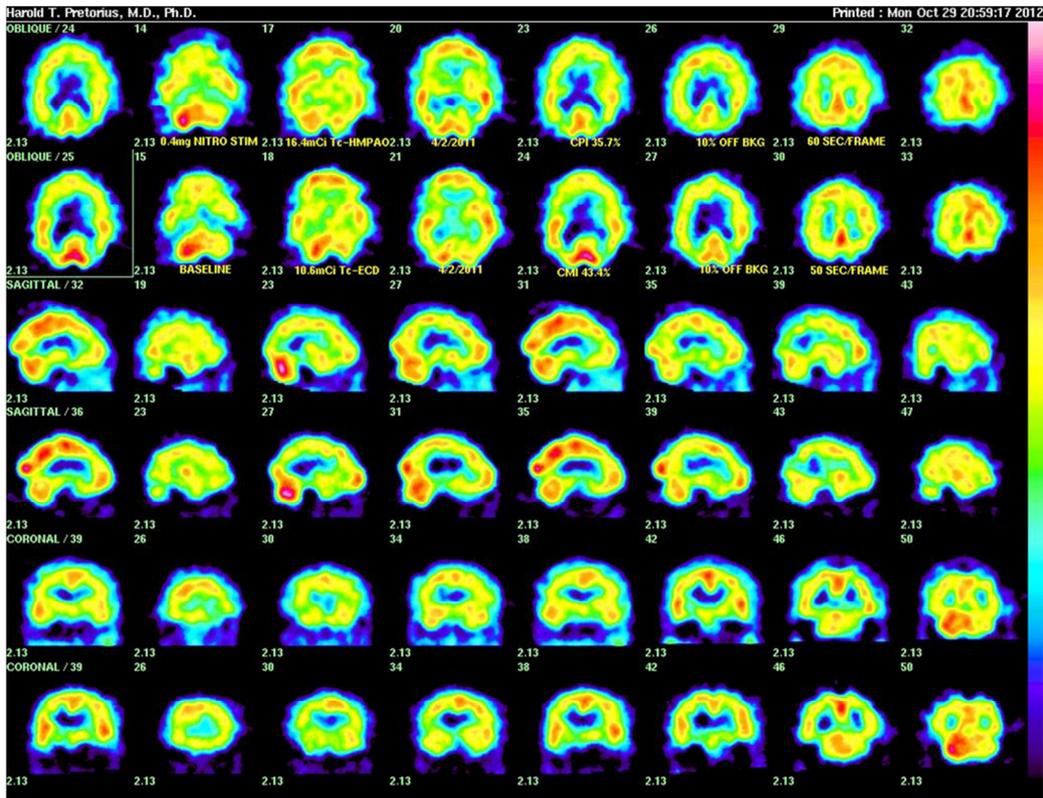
Brain SPECT for a 52 year-old diabetic man after a left hemispheric stroke shows compromised FRi -7.7% . This patient is the only one in our entire experience to have a stroke after a normal scan with normal FRi 12.9, CMi 59.6%, CPi 71.4% two years before his stroke. In addition to uncontrolled type 2 diabetes mellitus (HbA1c 11.0%) with frequent hypoglycemic episodes, this patient's additional stroke risk factors included greater than 4 packs per day cigarette smoking, hyperlipidemia, coronary artery disease requiring angioplasty, renal hyperfiltration with low serum creatinine 0.7 (normal 0.9-1.3) and nonadherence to medical therapy including antiplatelet therapy (aggrenox).
